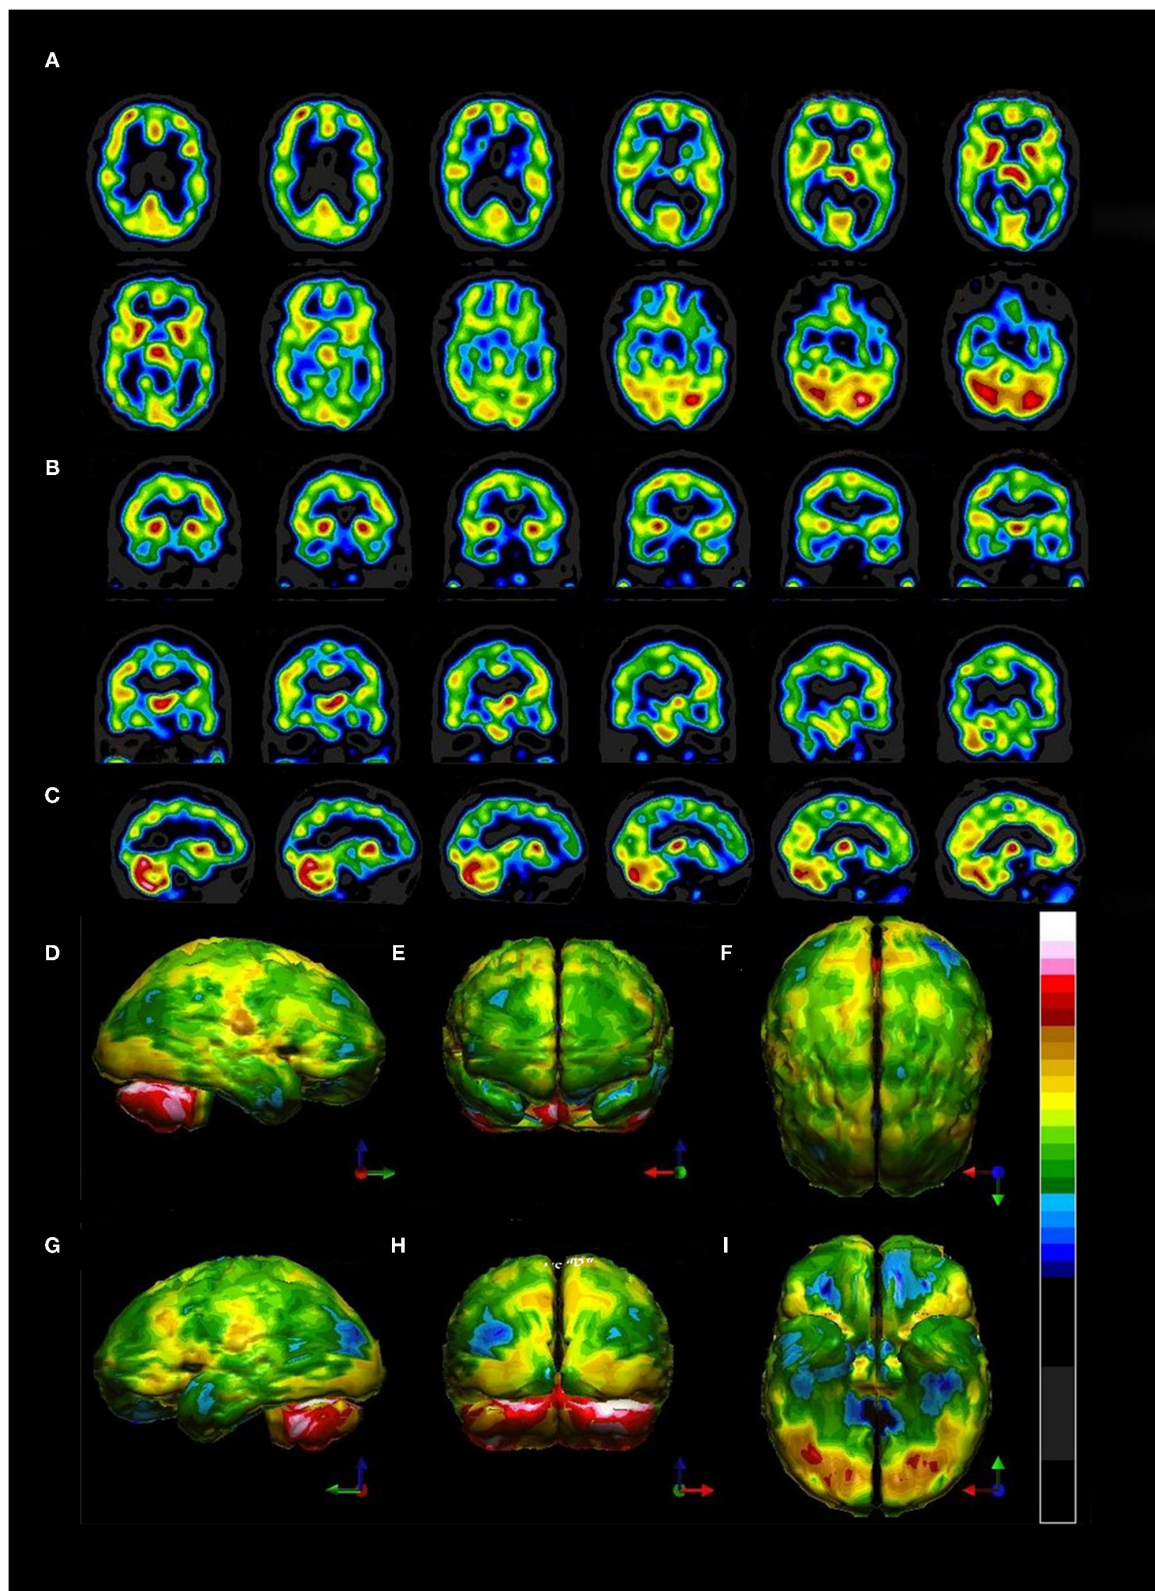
Tomograms and 3-D surface projections of perfusion SPECT scan showing diffuse hypoperfusion. (A) Selected transverse sections. Of note, the thalamus is neither hyper-perfused nor asymmetrical as is typically seen in bipolar disorder. (B) Selected coronal sections. The thalamus can be seen in a different orientation and is neither hyper-perfused nor asymmetrical. (C) Selected sagittal sections. (D–I) 3-D surface projection views show the highly diffuse nature of the hypoperfusion involving frontal, temporal, parietal, and even occipital cortices. (D) Left lateral view. (E) Anterior view. (F) Superior view. (G) Right lateral view. (H) Posterior view. (I) Inferior view with cerebellum removed. Color scale is the Ubiq40 color scale as described in Figure 5.
